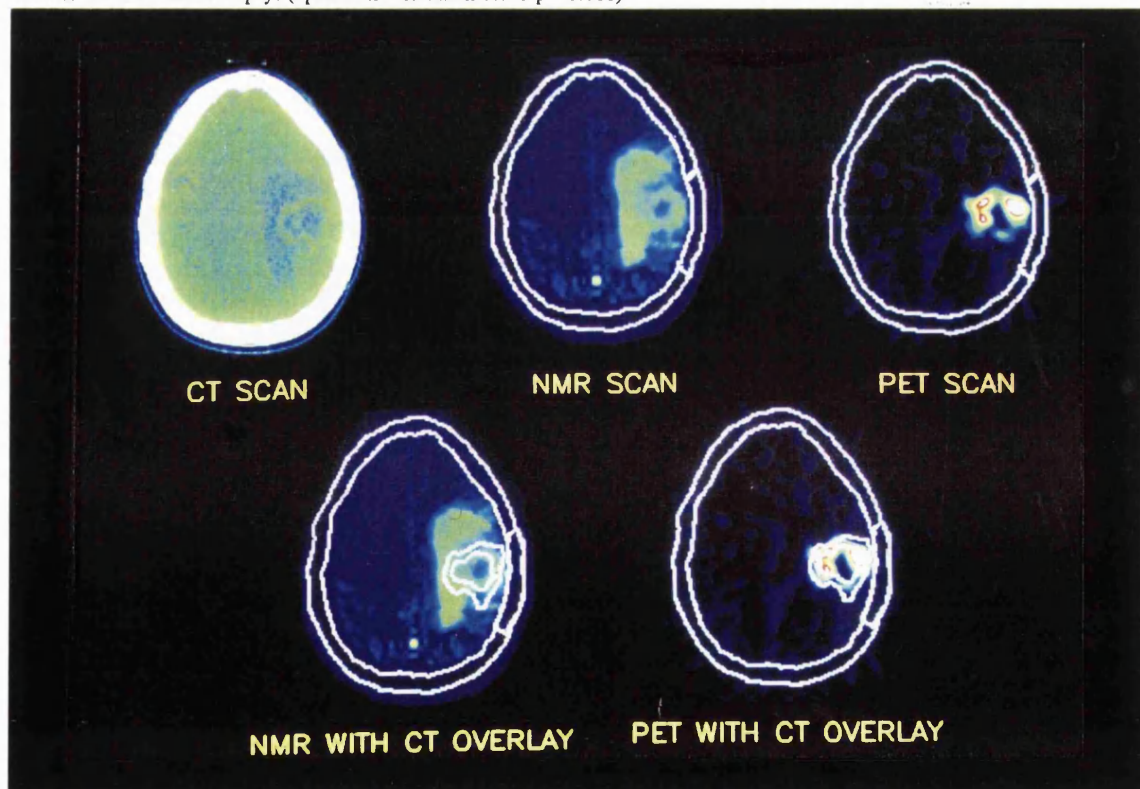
CT, MRI and PET images for patient 5. The MRI scan shows the surrounding oedema, but the active tumour is seen on the PET image.
